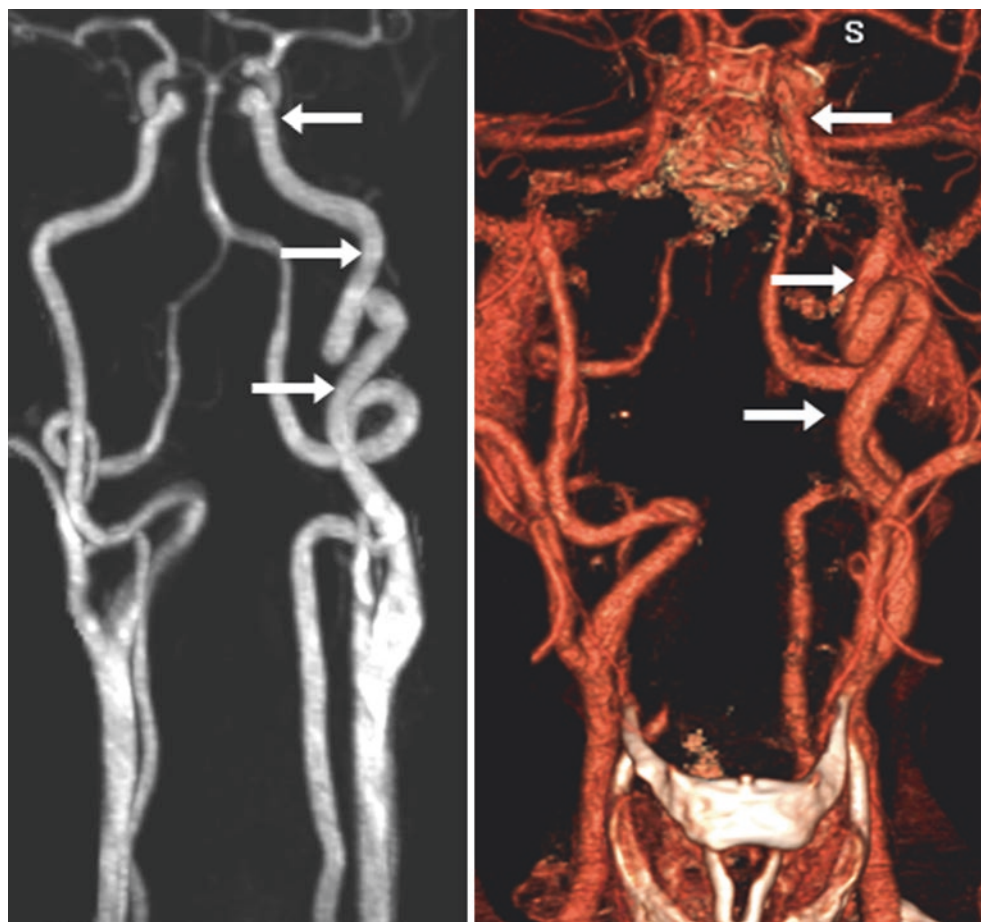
53-year-old with a moderately ectatic and tortuous left ICA diffusely (arrows) on AP views from a contrast-enhanced MRA (left) and CTA (right)
